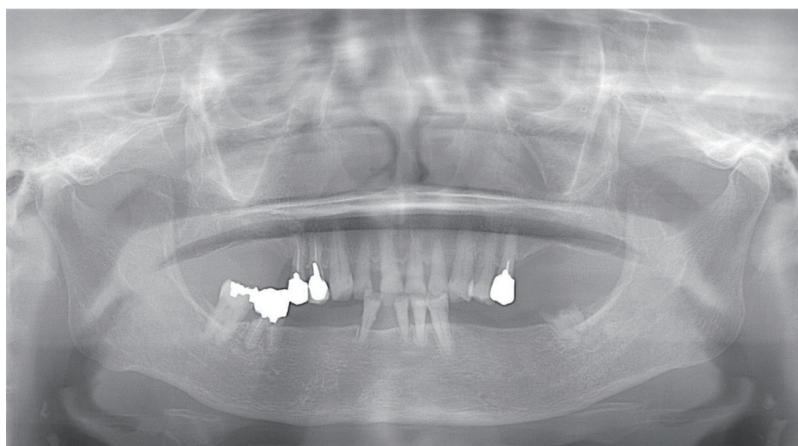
Panoramic X-ray at first visit
